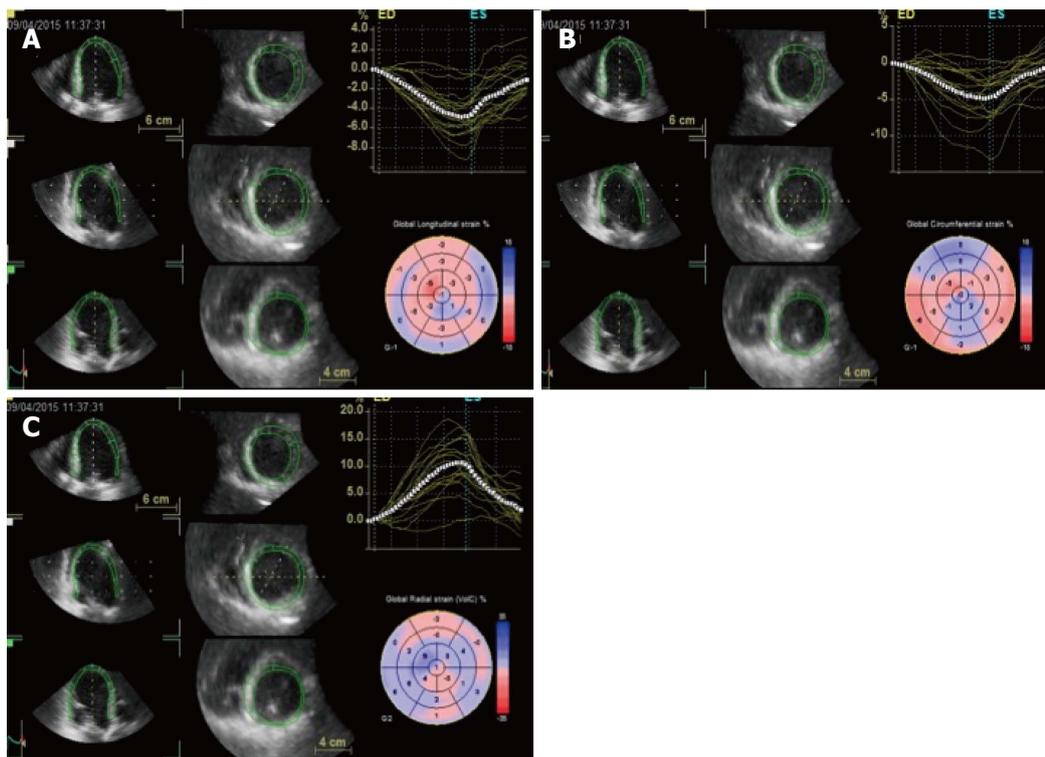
Three dimensional speckle tracking: data sets are displayed in different cross-sections including standard three short-axis views and apical four- and two-chamber views. The software automatically divides data into 16 standard segments to generate corresponding time–strain curves. Wall motion parameters are simultaneously displayed in particular, the 3 orthogonal strain values (longitudinal strain in A, circumferential strain in B and radial strain in C).
